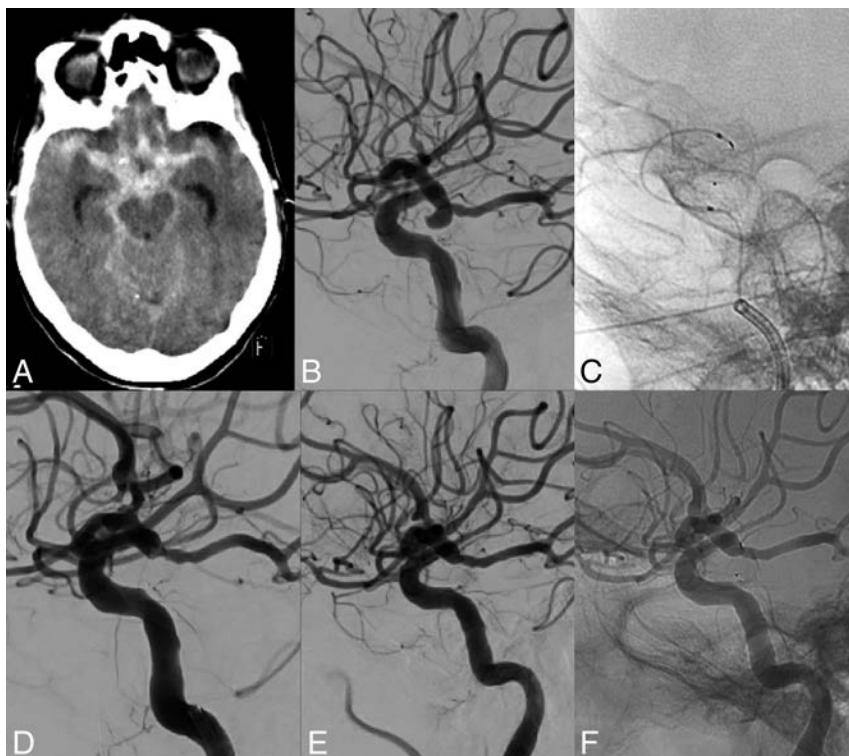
A 71-year-old woman (patient 32) with a ruptured posterior communicating artery aneurysm. A, CT scan shows diffuse subarachnoid blood. B, Lateral right internal carotid angiogram reveals a small posterior communicating artery aneurysm pointing downward. C, VIA 17 in a hairpin configuration after deployment of the WEB 17 SLS 6 mm inside the aneurysm. D, Immediate aneurysm occlusion after WEB 17 placement. E and F, Three-month follow-up angiogram demonstrates persistent complete aneurysm occlusion.
